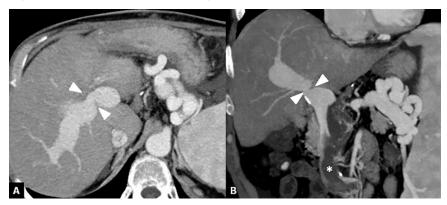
Portal vein stenosis. (a, b) Axial and coronal CT images show a severe portal vein stenosis (arrowheads) at site of the anastomosis. To note the presence of thrombus within the superior mesenteric vein (asterisk).
